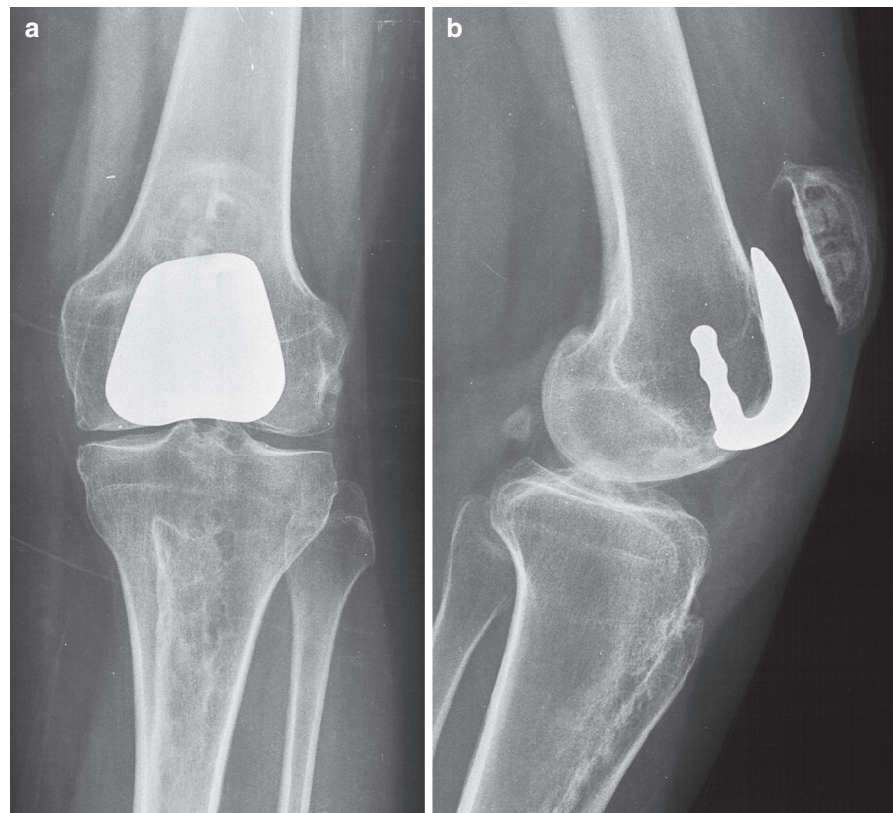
Anteroposterior (a) and lateral (b) radiographs of the left knee showing a patella alta and a patellofemoral arthroplasty
